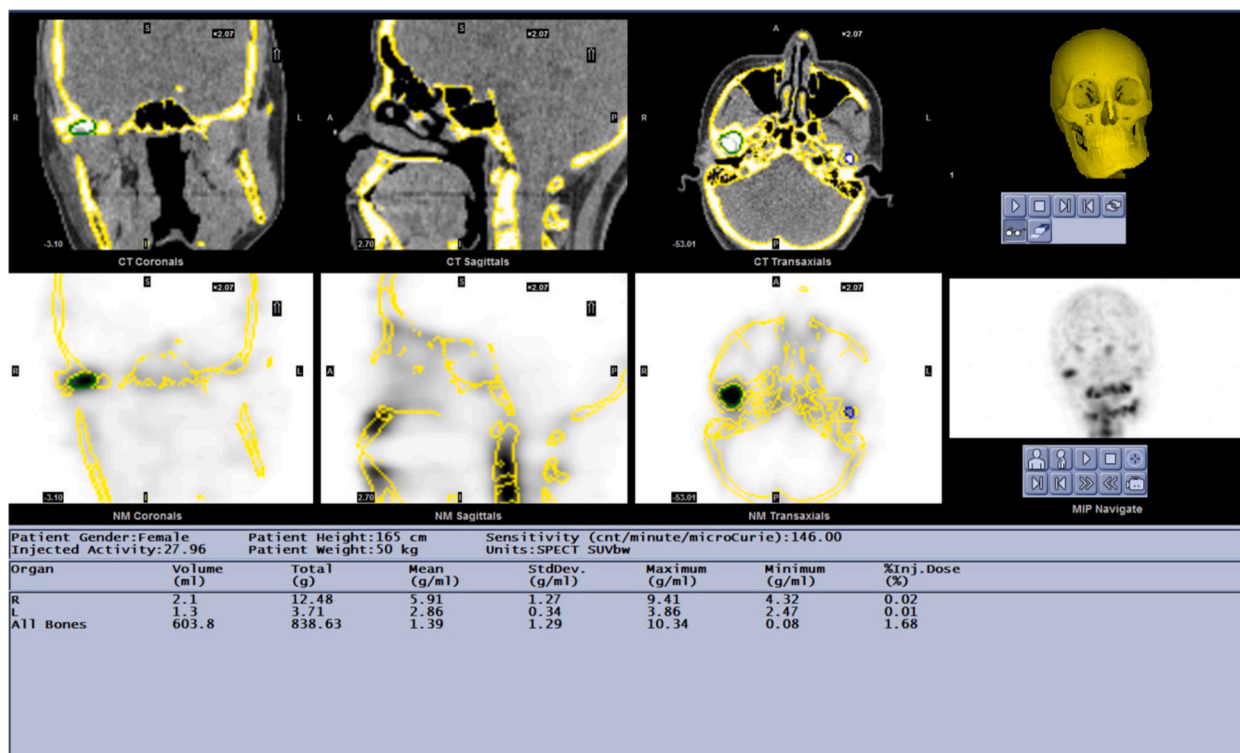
An example picture of quantitative analysis with SPECT/CT.
